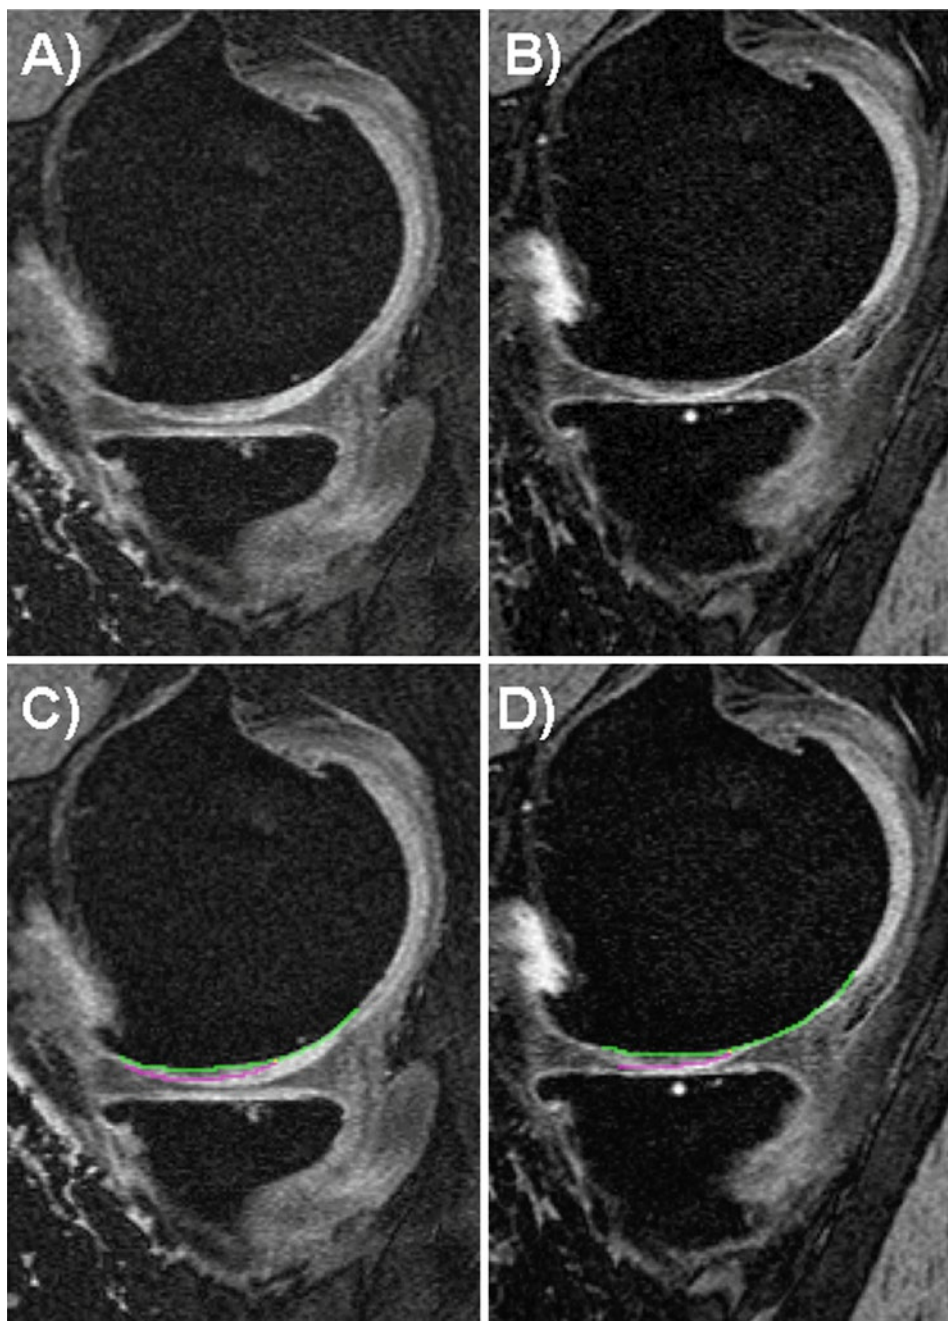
Sagittal 3D DESS MR images acquired at baseline (a, c) and at 12-months follow-up (b, d). Images (a) and (c) are without and images (b) and (d) are with segmentation. The green lines show the outline of the total area of subchondral bone (tAB) in the cMF, and the magenta line shows the outline of the area of the cartilage surface (AC)
